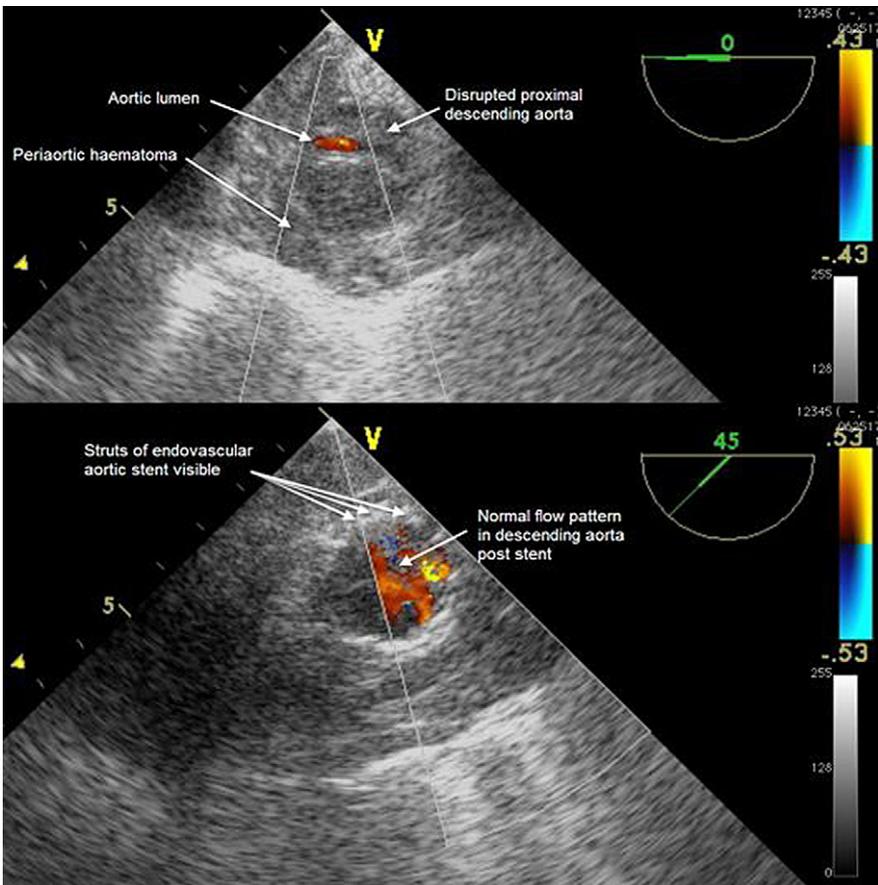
Transoesophageal echocardiography images of the proximal descending aorta showing disruption and near complete occlusion of the lumen (upper panel). The lumen has been restored by placement of an endoluminal stent (lower panel).
